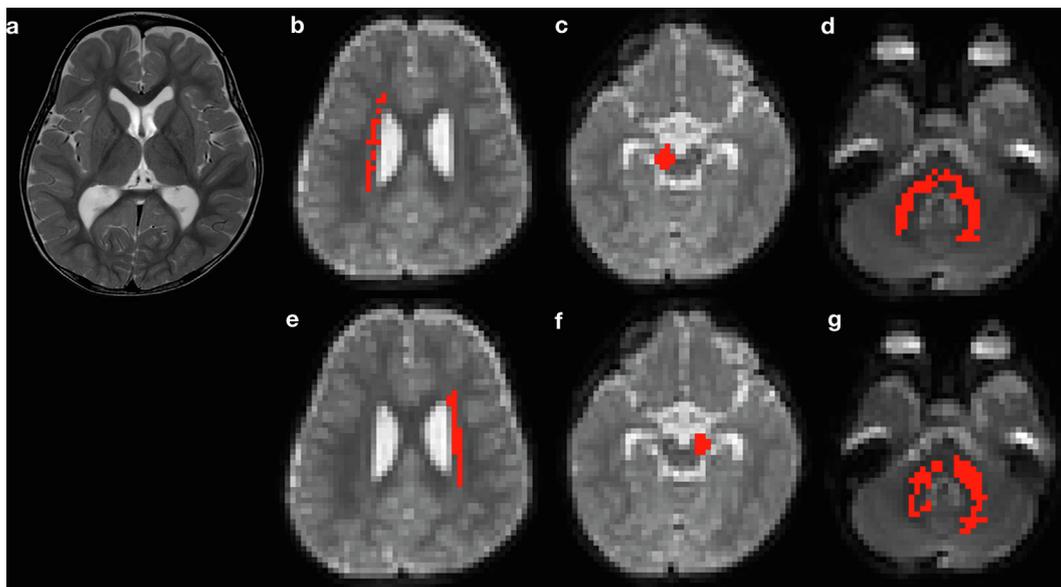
A 1-year-and-8-month-old disease control; bilateral pattern. a: T2-weighted image shows no apparent abnormal findings other than mild atrophy. b–d: Tractography shows bilateral cerebellar distributions of CPC tracts when the ROI is placed in the right cerebral peduncle. e–g: The same on the left side.
